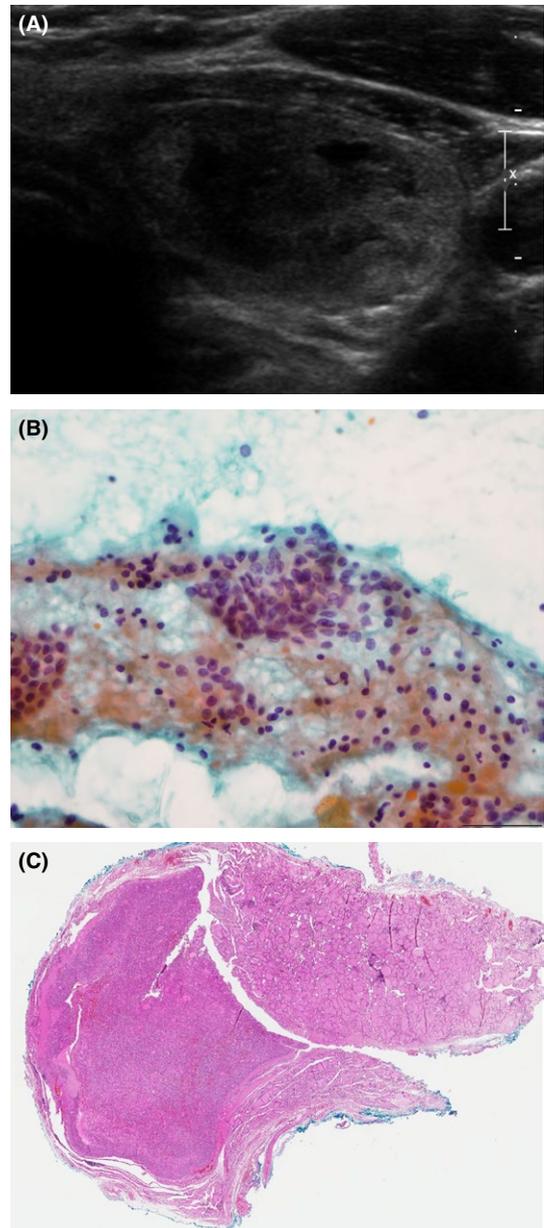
An example of a NIFTP with a low US category and high Bethesda category. (A) An approximately 3.2 cm category 3 nodule based on both ATA guidelines and K-TIRADS shows a smooth margin, isoechoic solid portion and parallel orientation with a small cystic portion. (B) The cytological result of the fine needle aspiration (FNA) for this nodule was malignant. The cytological image from the FNA ($\times 400$) shows the typical features of papillary thyroid carcinoma such as nuclear pseudoinclusions (C) The patient with this nodule underwent total thyroidectomy, and the final pathologic result was NIFTP. A low magnification image of the resected tumour ($\times 10$) shows a well demarcated margin suggesting NIFTP. If lobectomy was considered for the nodule with an US category of 4 or less, even though the cytopathological result was category 5 or 6, this patient could have avoided total thyroidectomy. ATA, American Thyroid Association; K-TIRADS, Korean Thyroid Imaging Reporting and Data System; NIFTP, noninvasive follicular thyroid neoplasm with papillary-like nuclear features; US, ultrasonography [Colour figure can be viewed at wileyonlinelibrary.com]
